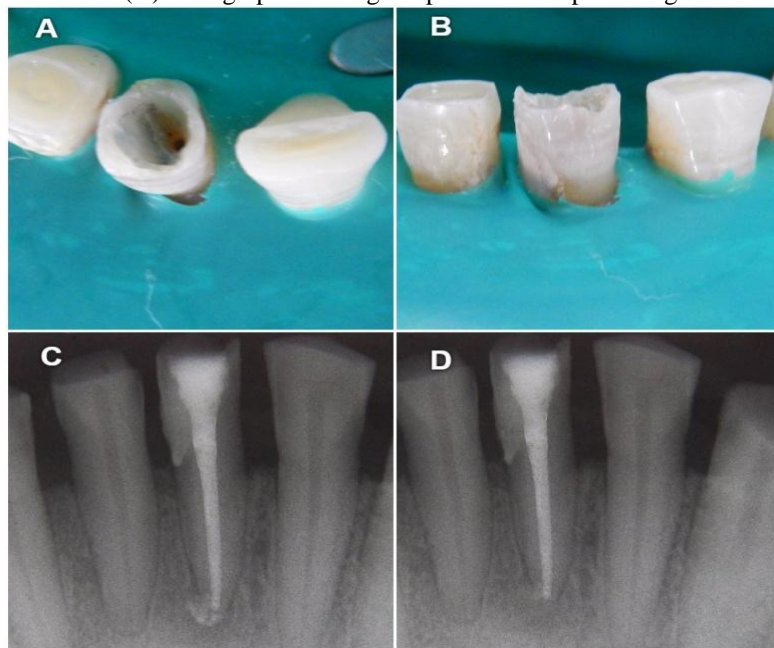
(A) & (B) clinical images showing the perforation repair using biodentine (C) obturation after observing the signs of healing periapical lesion (D) follow-up radiograph after 2 years
